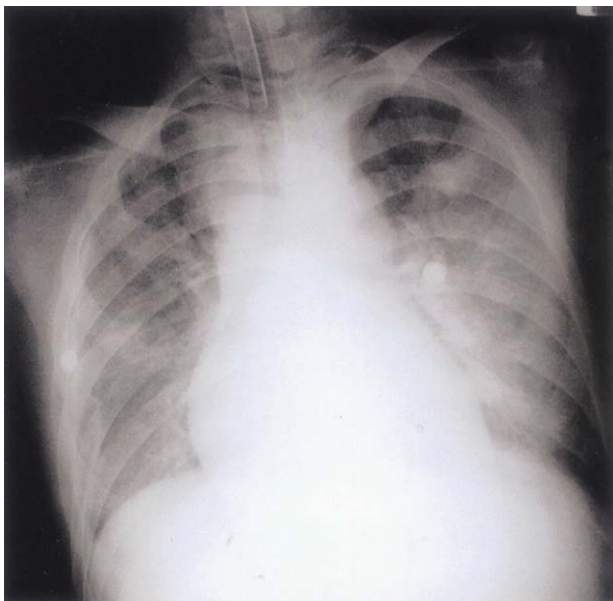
Chest X-ray on second hospital day, shows rapidly aggravated bilateral airspace consolidation.
